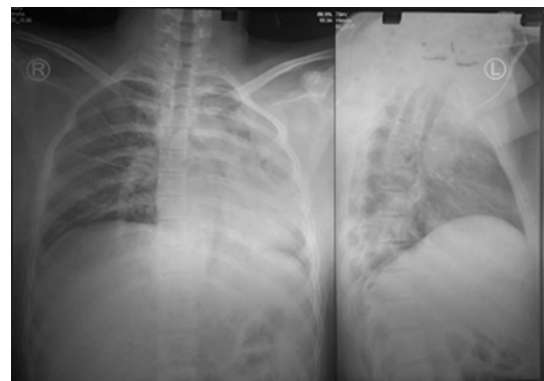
Plain chest radiograph after flexible bronchoscopy. A. Anteroposterior, B. Lateral
